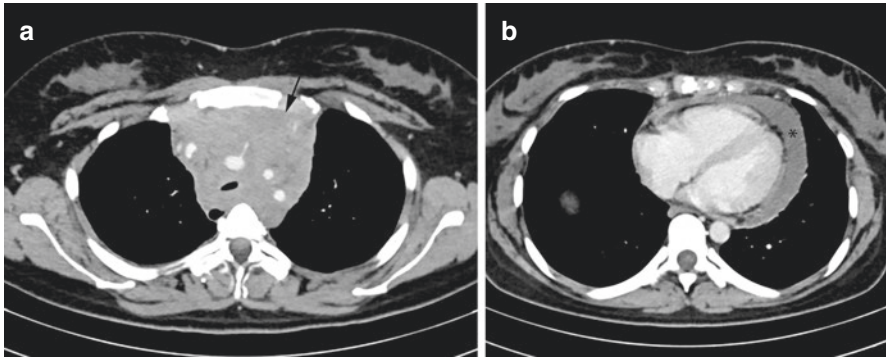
Pericardial effusion in a patient with mediastinal lymphoma. (a) and (b) axial contrast enhanced CT images show infiltrating mediastinal mass, encasing trachea, and mediastinal vessels, and pericardial effusion
